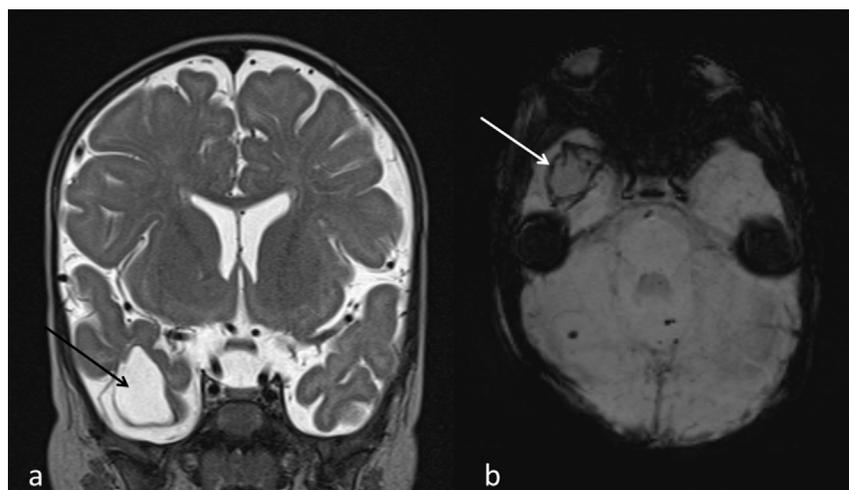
Mild gross motor delay with axial hypotonia in a 5-month-old infant. a) MRI shows a right temporal porencephaly (coronal T2-weighted image). b) On specific sequences (SWI; axial view) with susceptibility to blood content, blood products deposits on the wall of the cavity are well demonstrated.
